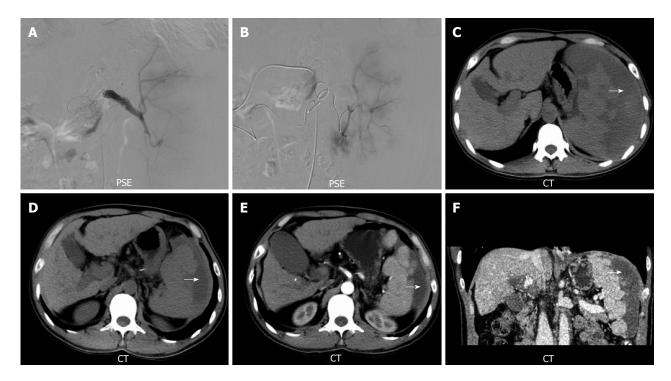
Partial splenic embolization therapy. A: Partial splenic embolization (PSE) therapy through the collateral artery of dorsal pancreatic artery; B: PSE therapy through the left gastro-epiploic artery; C: Abdominal computed tomography (CT) revealed that ischemic infarction (black arrow) was seen in the spleen 2 wk after PSE; D-F: Follow-up abdominal CT was performed after 4 mo (D) and 9 mo (E and F), showing that the size of the spleen and infarction (black arrows) progressively decreased.
